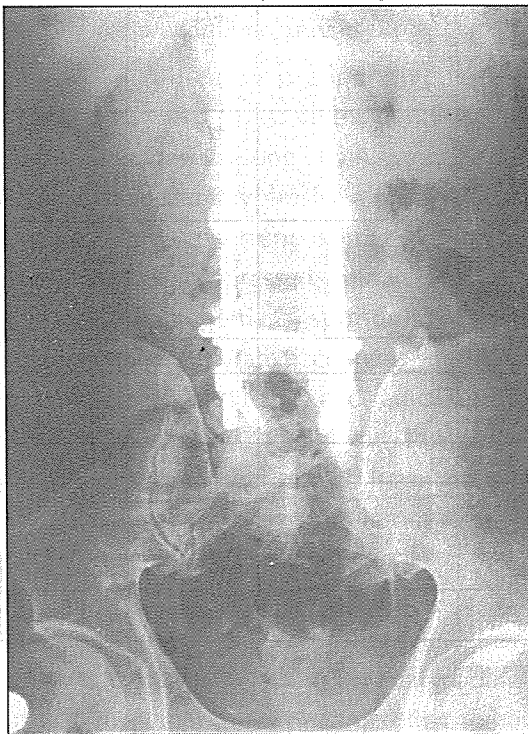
Postoperative antero-posterior roentgenogram of the same patient after total bilateral laminectomy, posterolateral fusion and posterior instrumentation.
